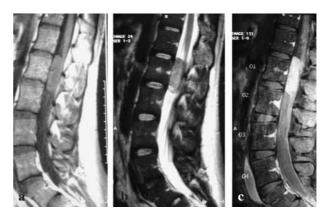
Sagittal T1-weighted MR image showing a cylindrical, elongated mass $(1.2 \text{ cm} \times 4.5 \text{ cm})$, isointense relative to the normal cord (a). On T2-weighted image, the tumour is slightly hyperintense (b). As seen on both T1 and T2 images it is located just below the conus medullaris at the spinal level of the L1 vertebra. After contrast administration it shows a fairly intense enhancement with well-defined borders (c).
